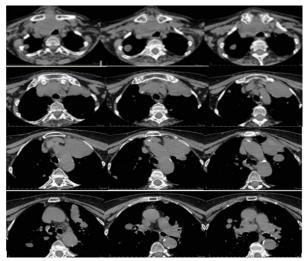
CT of the Upper Mediastinum/October 2021-The tumor in the cervical right region descends behind the sternum and covers the anterior upper mediastinum mainly to the right, and subsequently to the left, pushes the trachea and hypopharynx and infiltrates the upper left lung lobe. Bilaterally in the lung parenchyma, diverse diffuse nodular soft tissue lesions.
